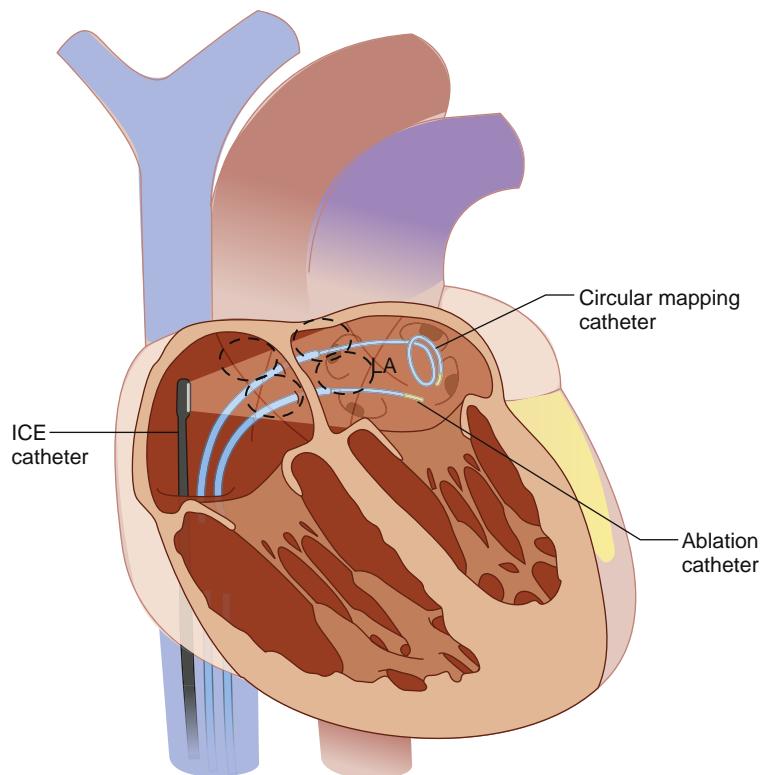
Catheter placement during ablation procedures. Mapping and ablation catheters were placed under the guidance of intracardiac echocardiography. ICE, Intracardiac echocardiography LA, Left atrium. (Courtesy O. Wazni, MD, Cleveland Clinic, Cleveland, OH.)
